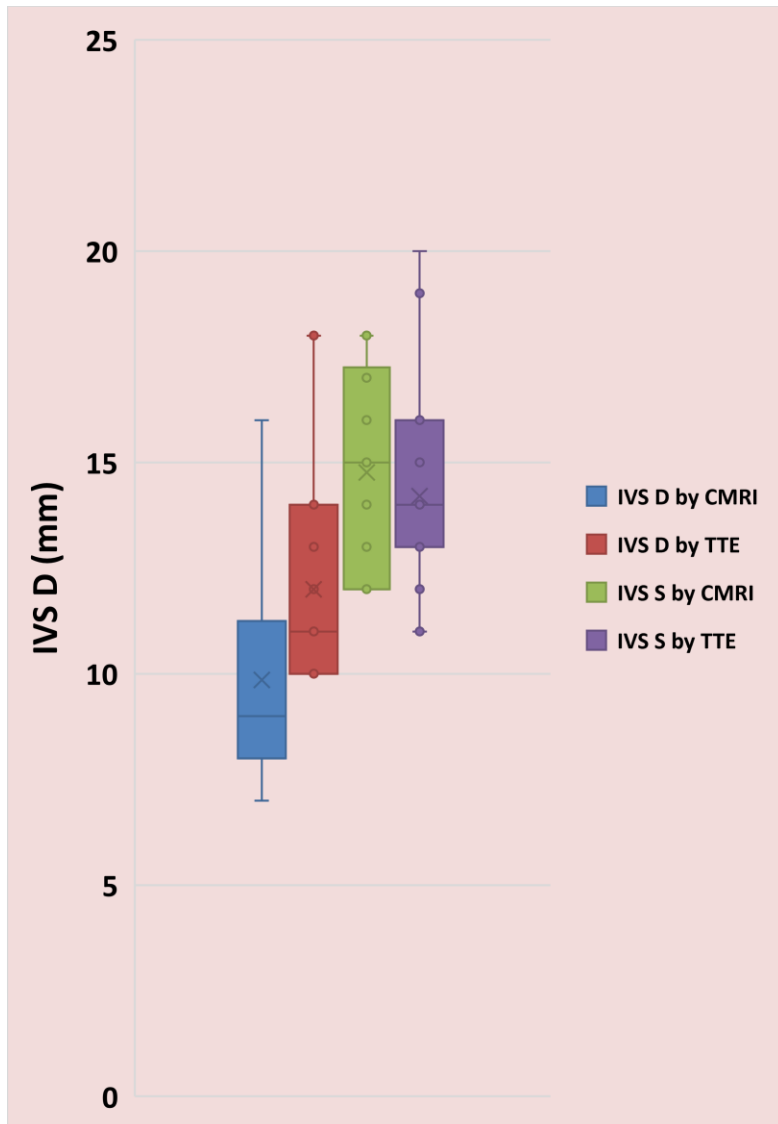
Comparison of inter-ventricular septum (IVS) thickness by transthoracic echocardiography (TTE) and cardiac MRI.
